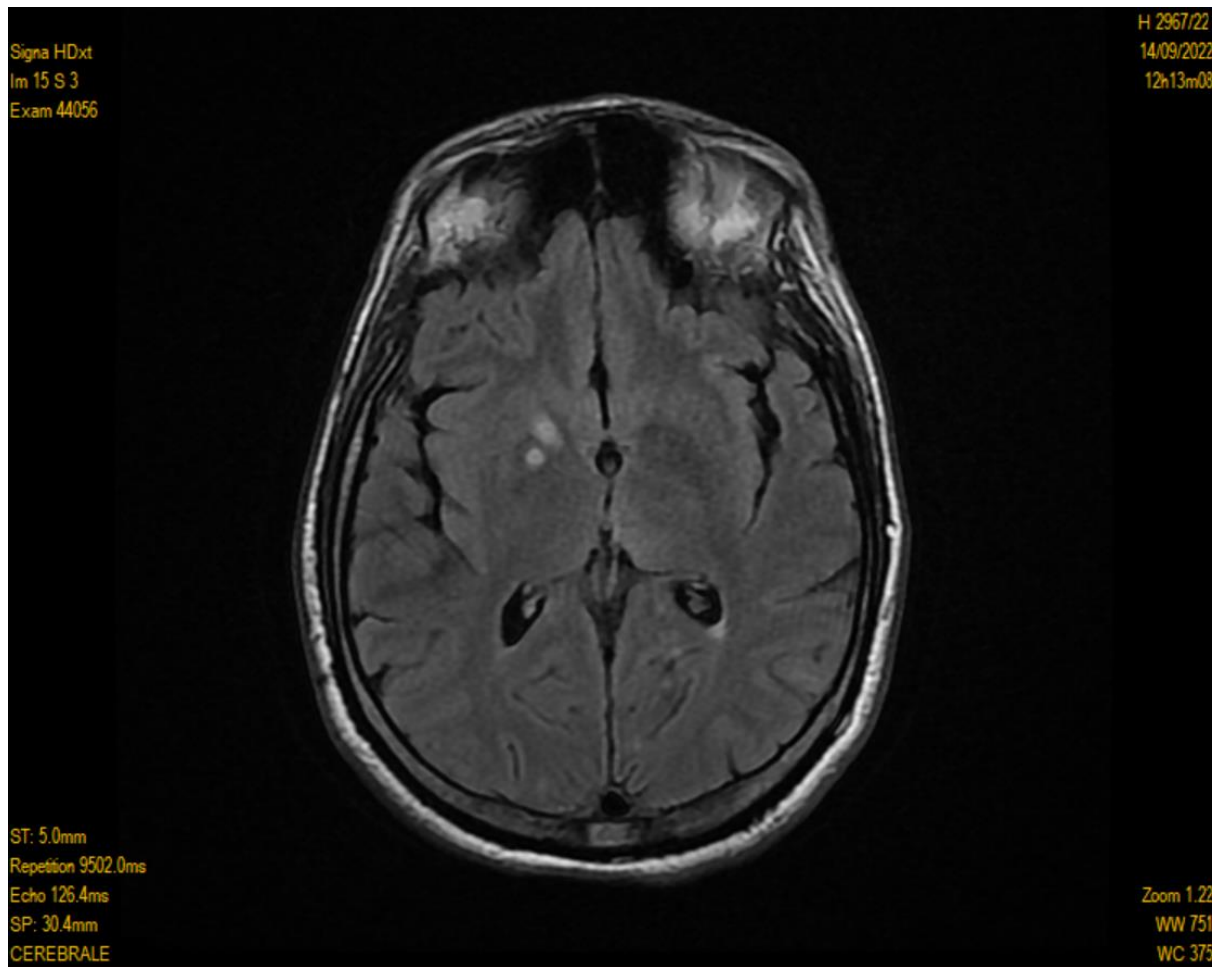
Toxoplasmic abscesses in the right basal ganglia are hyperintense on FLAIR sequence.*
